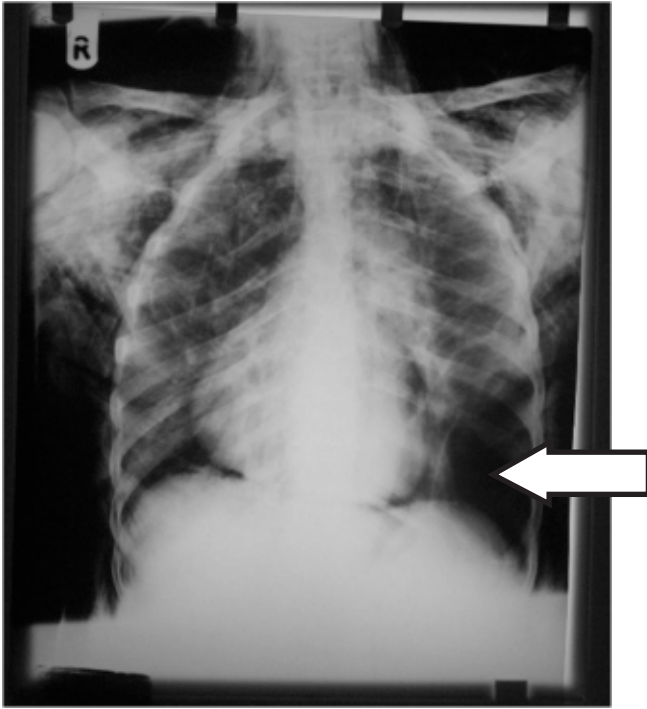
Plain chest radiograph of patient with extensive traumatic emphysema. Note area of partial pneumothorax / pleural symphysis (arrow head).
